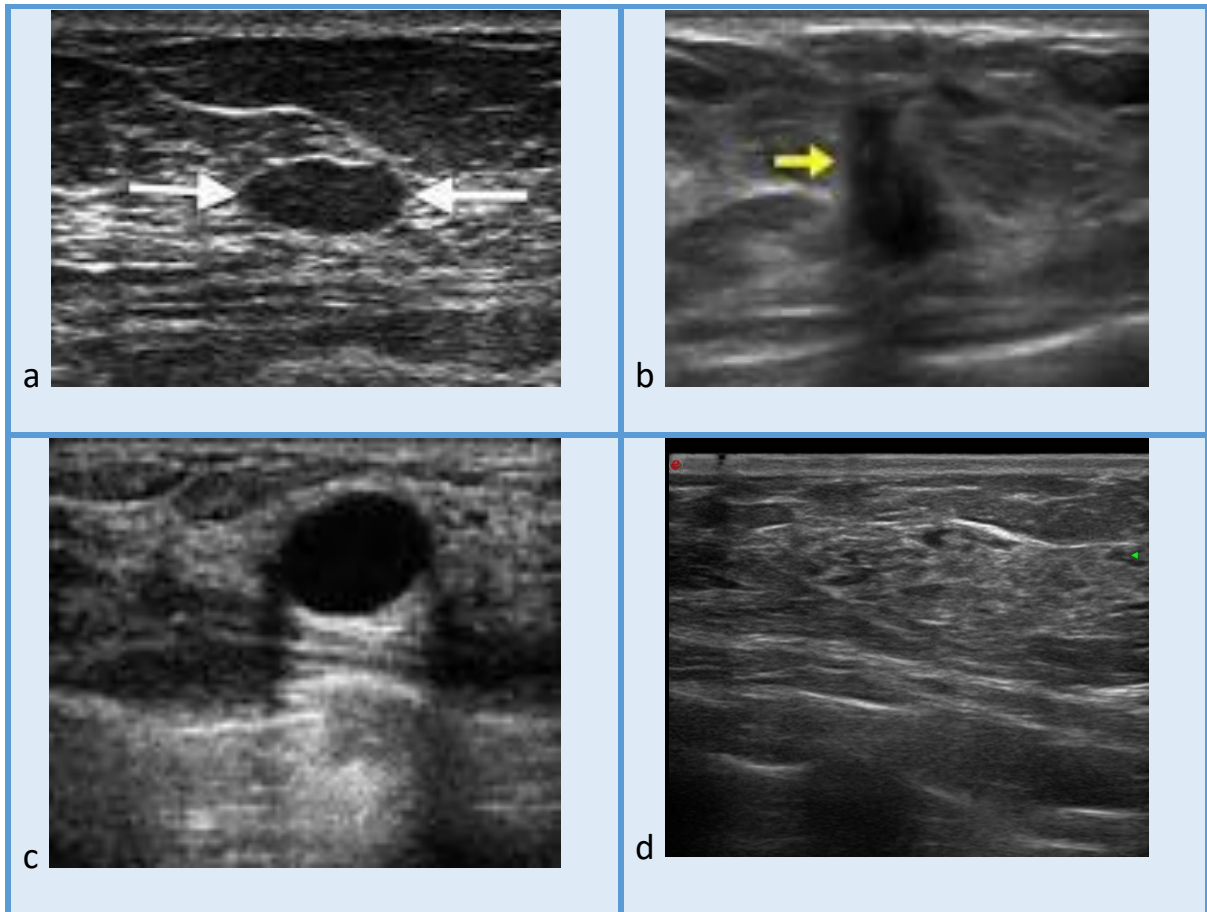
Ultrasounds with different diseases. a-Round oval benign mass, b-Taller than wide mass, c-Cyst, d-Adenopathy
